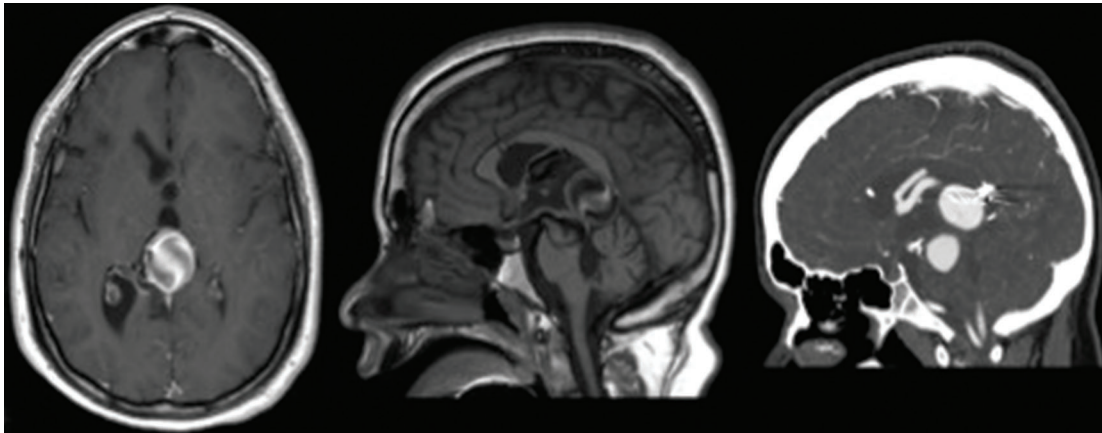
Axial (left) and sagittal (middle) T1 weighted MRI with gadolinium, and sagittal CT scan (right) of unsecured AV fistula.
